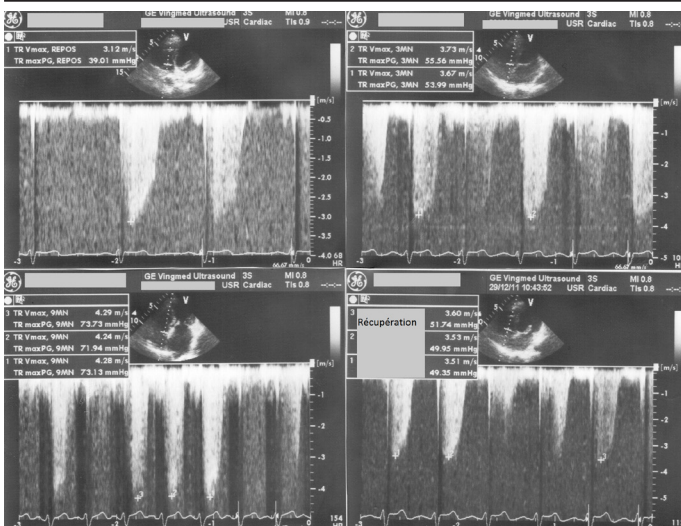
Profile of SPAP in effort Doppler echocardiography.
